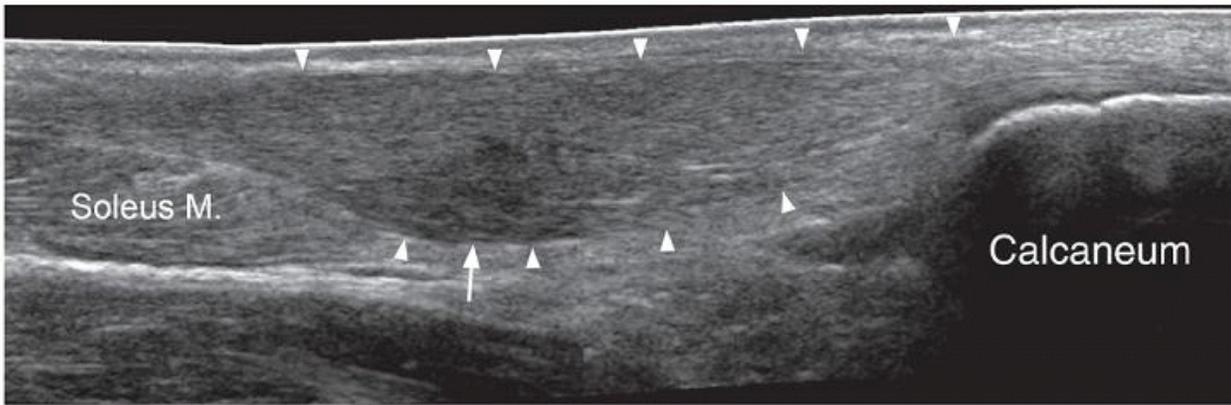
Longitudinal extended-field-of-view ultrasound showing diffusely thickened Achilles tendon (arrowheads) in patient with familial hypercholesterolemia. The tendon thickening is due to deposition of cholesterol-rich material between the collagen fibers. There is a more discrete hypoechoic area of cholesterol deposition on the deeper aspect of the mid-tendon, which could be termed a “xanthoma” (arrow).
